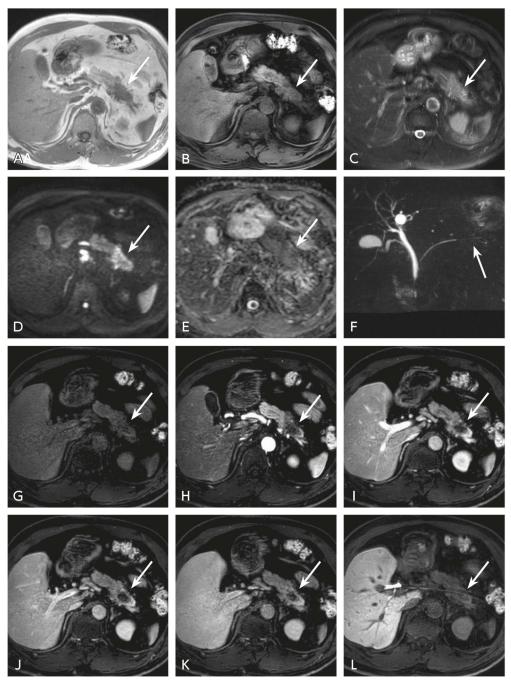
MRI of pancreatic tail cancer
